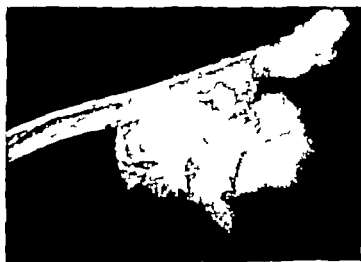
Roentgenogram of a surgically extirpated peripheral chondrosarcoma protruding from the inner aspect of a rib. Only the older central portion of the tumor is heavily calcified. This neoplasm developed insidiously and was discovered by chance in a chest film taken because the patient had developed pneumothorax following an injury. The pleura was not yet invaded by tumor and the prospect for cure in this instance is good.
